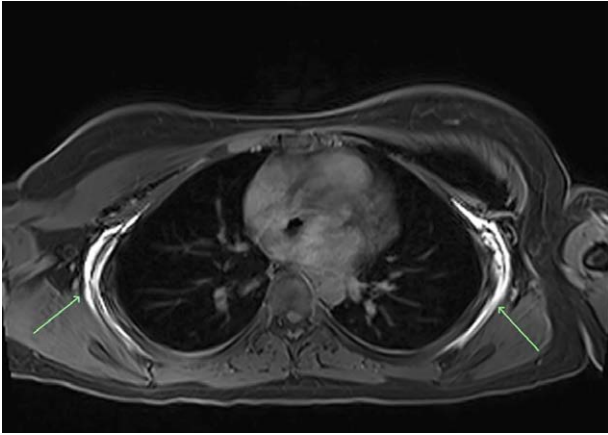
Coronal MRI demonstrating subserratus block.
